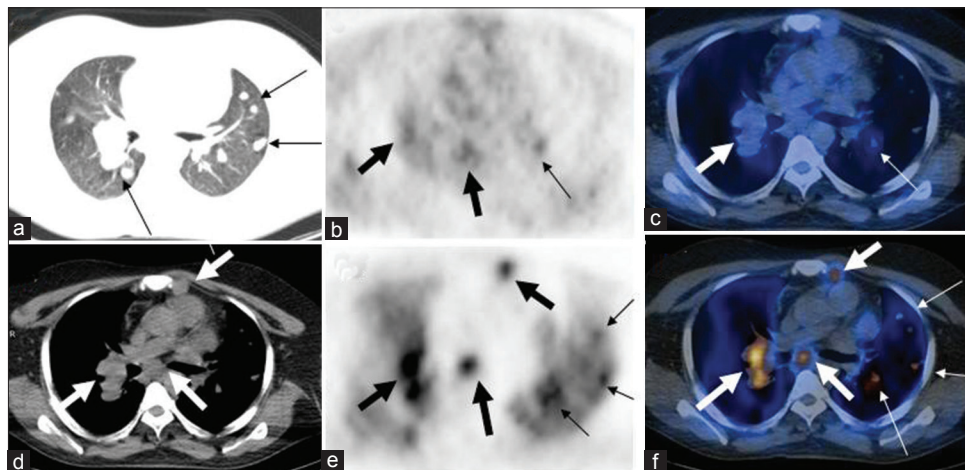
Transaxial CT in lung window (a) shows metastatic pulmonary nodules, which show low-grade FDG avidity but significant ^{11}C -methionine uptake on the transaxial PET (thin arrows in b and e) and fused PET/CT image (thin arrows in c and f), respectively. Transaxial CT (d) shows right hilar, subcarinal, and left internal mammary nodes (mediastinal window). Significant ^{11}C -methionine uptake also noted on the PET (e) and PET/CT fusion image (f) at these sites (thick arrows). The corresponding FDG PET and PET/CT fusion images (b and c) show low-grade uptake (thick arrows). CT = Computed tomography, FDG = Fluorodeoxyglucose, PET = Positron emission tomography.
